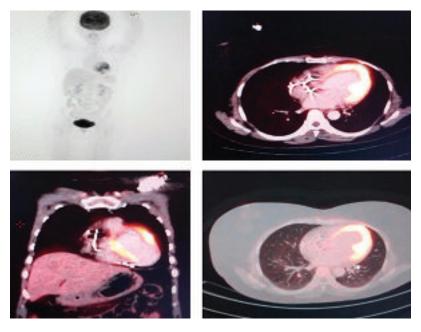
A,B,C,D: 18F-flurodeoxyglucose positron emission tomography (FDG-PET) of whole body showed only cardiac involvement.
